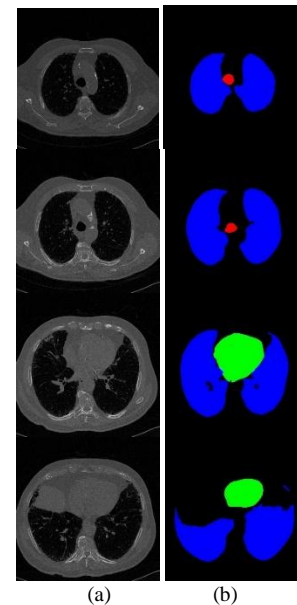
Samples from the Chest-CT-segmentation dataset, (a) CT images and (b) Corresponding masks.
